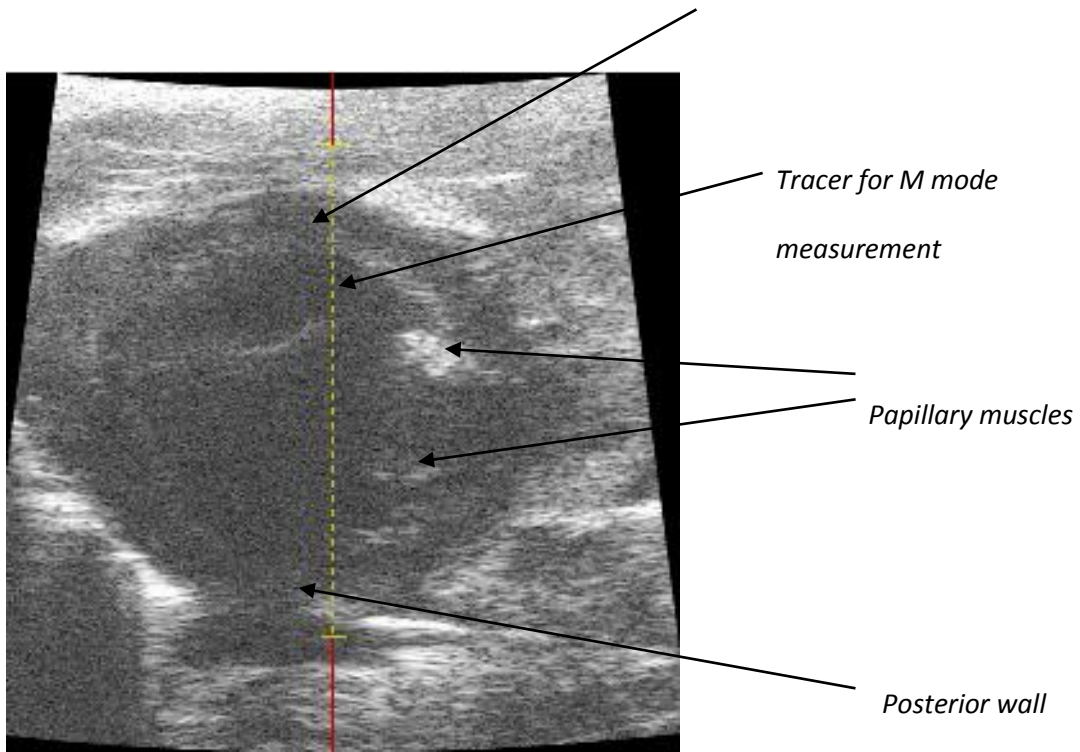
Parasternal short axis view (2D): left ventricle.
